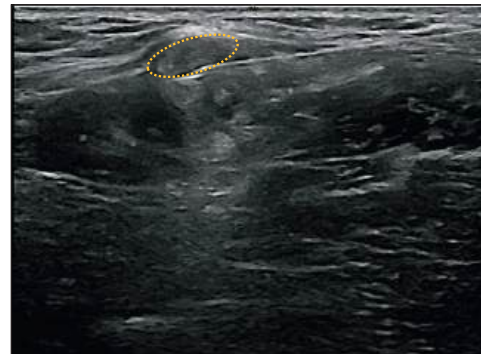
Sonographic view of injectate around the lateral femoral cutaneous nerve.
